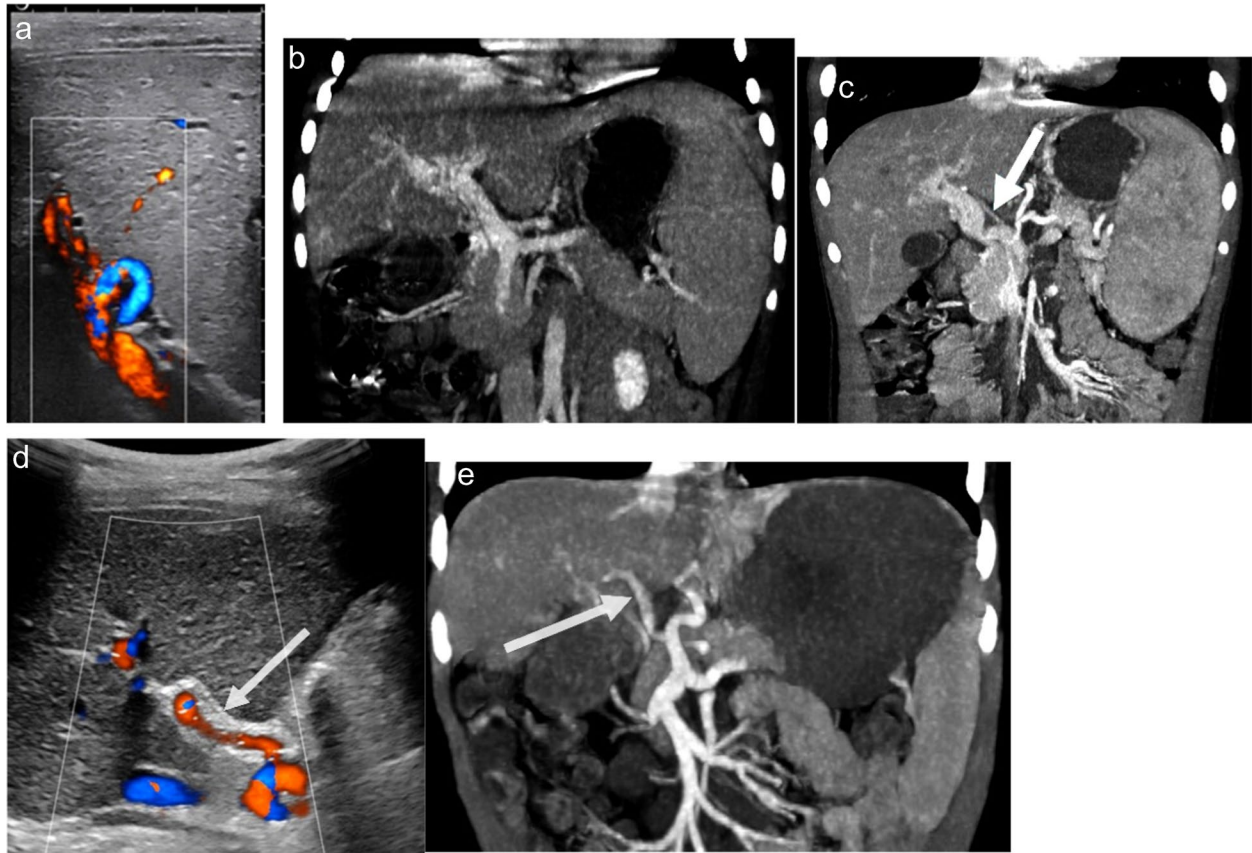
Pitfalls in the evaluation of extrahepatic portal vein obstruction (EHPVO) in a 5-year-old boy referred for the unconfirmed suspicion of EHPVO with cavernous transformation (a, b), an 11-year-old boy referred for EHPVO (c), and a 1-year-old boy referred for portal hypertension of unknown origin (d, e). a Colour Doppler ultrasound intercostal view shows the hepatic hilum with the simultaneous visibility of a patent portal vein and collateral venous circulation not consistent with EHPVO. b Coronal-reformatted maximum intensity projection (MIP) contrast-enhanced CT (CE-CT) confirms the coexistence of a patent main portal vein and parallel periportal collateral
